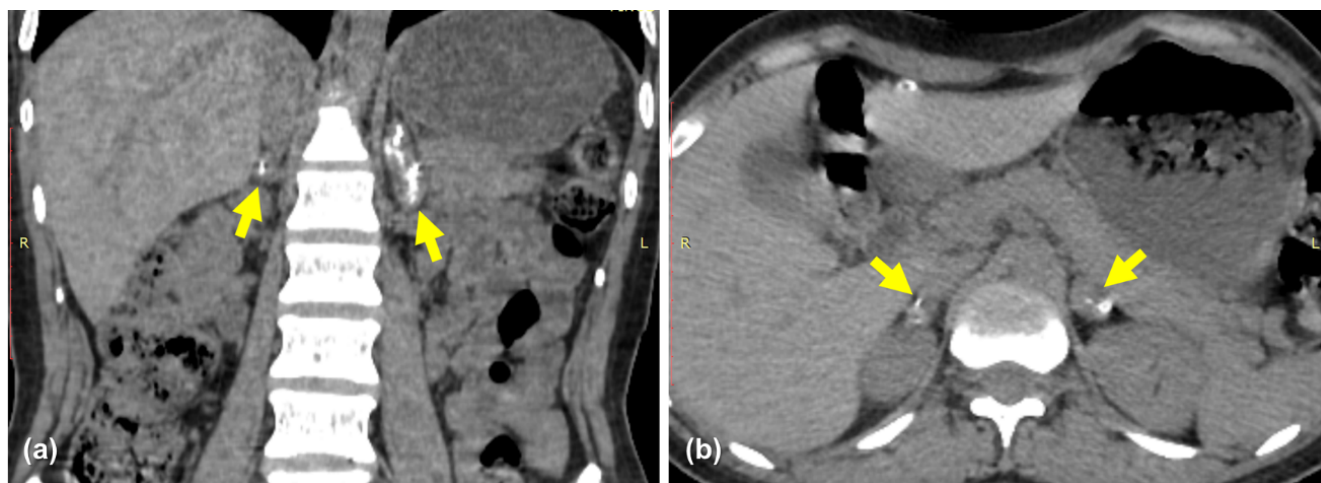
Non-contrast-enhanced multislice spiral CT of the adrenal glands. Enlarged adrenal glands with calcifications were evident in the (a) axial and (b) coronal planes (yellow arrows). (A higher resolution / colour version of this figure is available in the electronic copy of the article).
